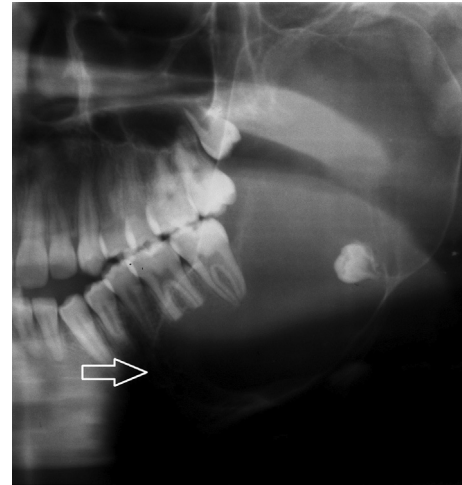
Preoperative panorex radiograph showing extensive unicystic ameloblastoma into the left mandibular ramus and condyle regions that recurred post marsupialisation.
